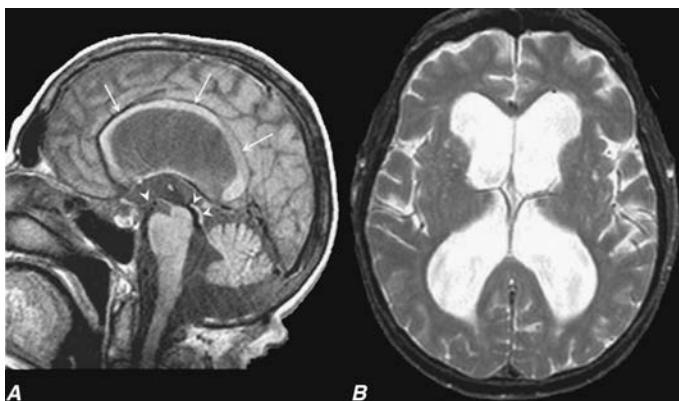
Normal pressure hydrocephalus. A. Sagittal T1-weighted MRI demonstrates dilation of the lateral ventricle and stretching of the corpus callosum (arrows), depression of the floor of the third ventricle (single arrowhead), and enlargement of the aqueduct (double arrowheads). Note the diffuse dilation of the lateral, third, and fourth ventricles with a patent aqueduct, typical of communicating hydrocephalus. B. Axial T2-weighted MRIs demonstrate dilation of the lateral ventricles. This patient underwent successful ventriculoperitoneal shunting.
